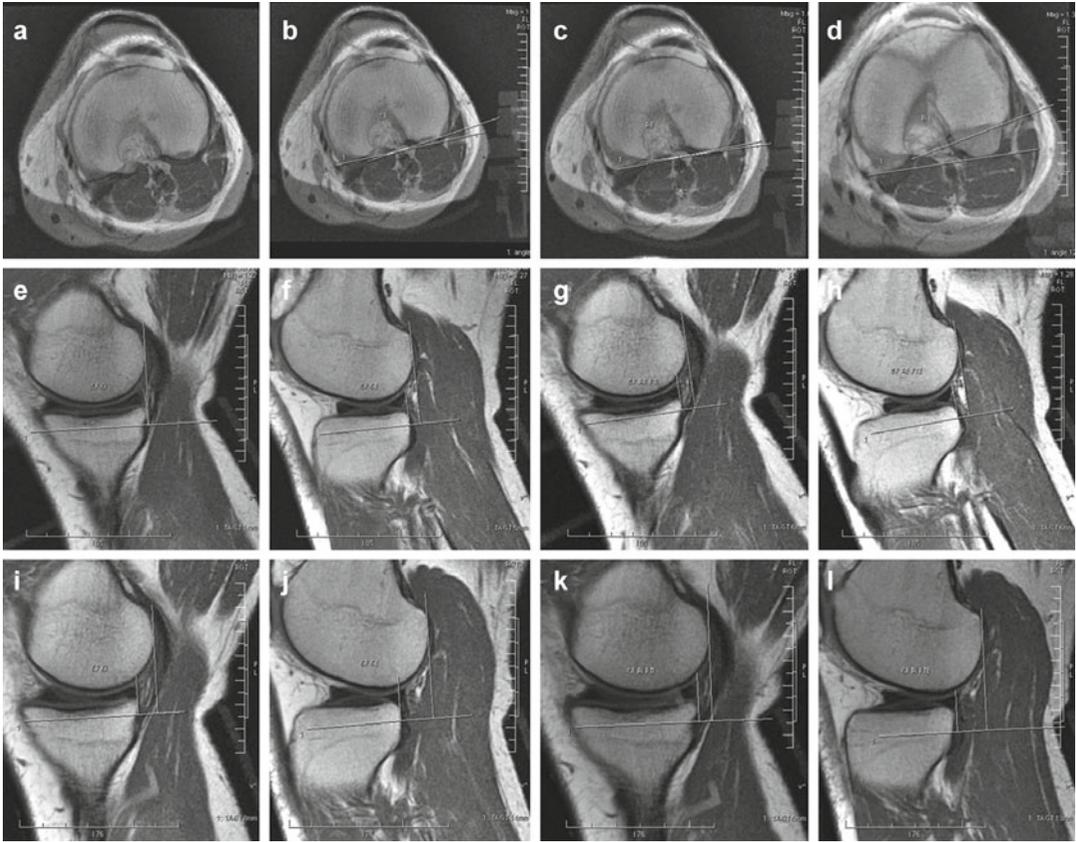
MRI-PKTD[®] evaluation of a patient with ACL rupture: (a) choice of the adequate image for bony landmarks; (b) posterior intercondylar line and posterior tibial line without pressure (5°); (c) angle with load application in anterior direction and external rotation (3°); (d) angle with load application in anterior direction and internal rotation (12°); (e) sagittal view without load, distance between medial posterior condyle and medial tibial plateau (1 mm); (f) sagittal view without pressure, distance between lateral posterior condyle and lateral tibial plateau (5 mm); (g) sagittal view without anterior pressure but with external rotation, distance between medial posterior condyle and medial tibial
